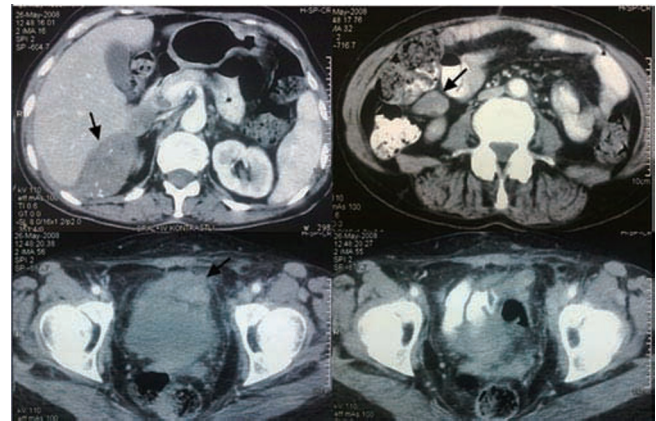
Postoperative 3rd month control CT images; soft tissue masses at different locations, including liver, pelvis and between bowels.
